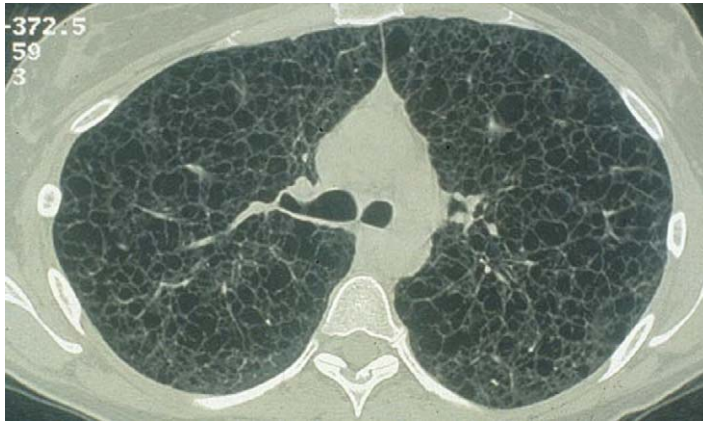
Chest CT scan of a patient with LAM shows characteristic bilateral cysts of various sizes.
